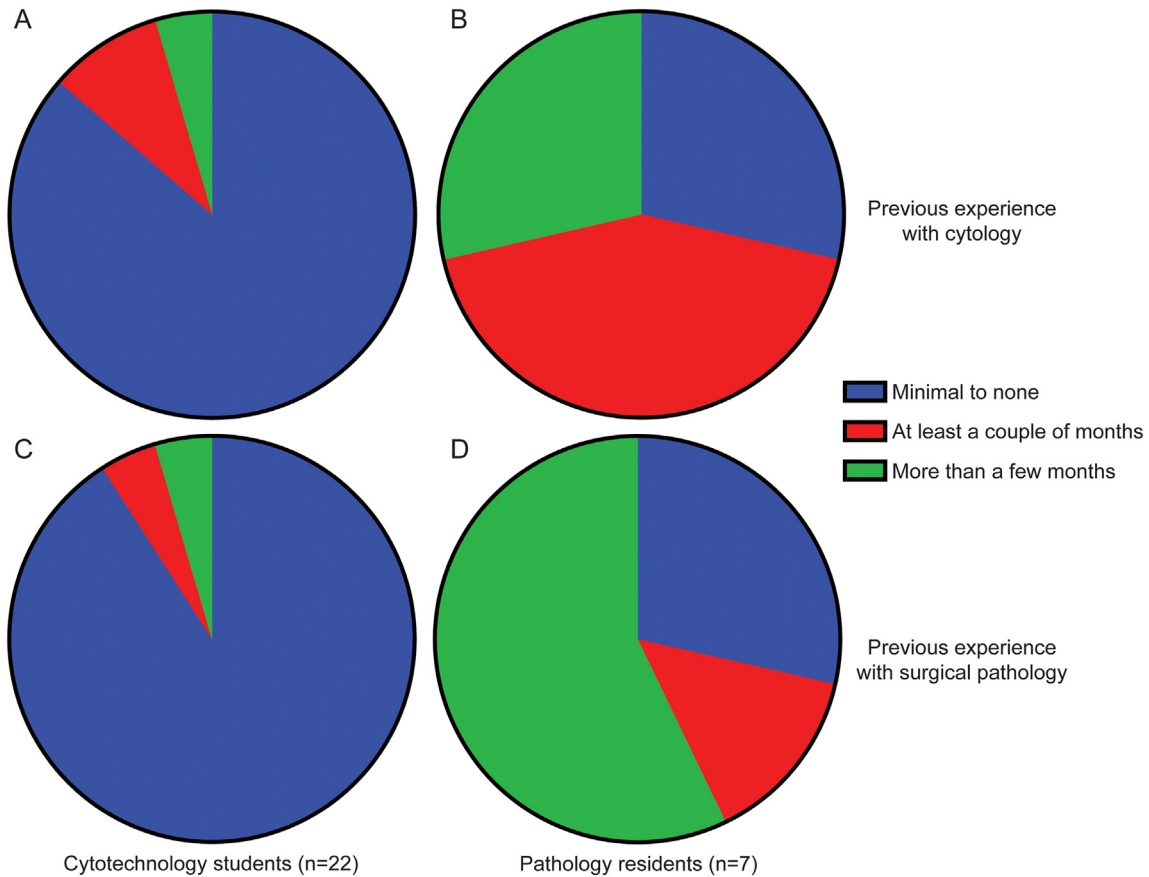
Previous exposure of respondents to thyroid cytopathology or surgical pathology by training program. (A, C) Cytotechnology (CT) students' previous experience with thyroid cytology and surgical pathology, respectively. (B, D) Pathology residents' previous experience with the same. The great majority of CT students did not have previous exposure to either field, whereas residents were mixed.
